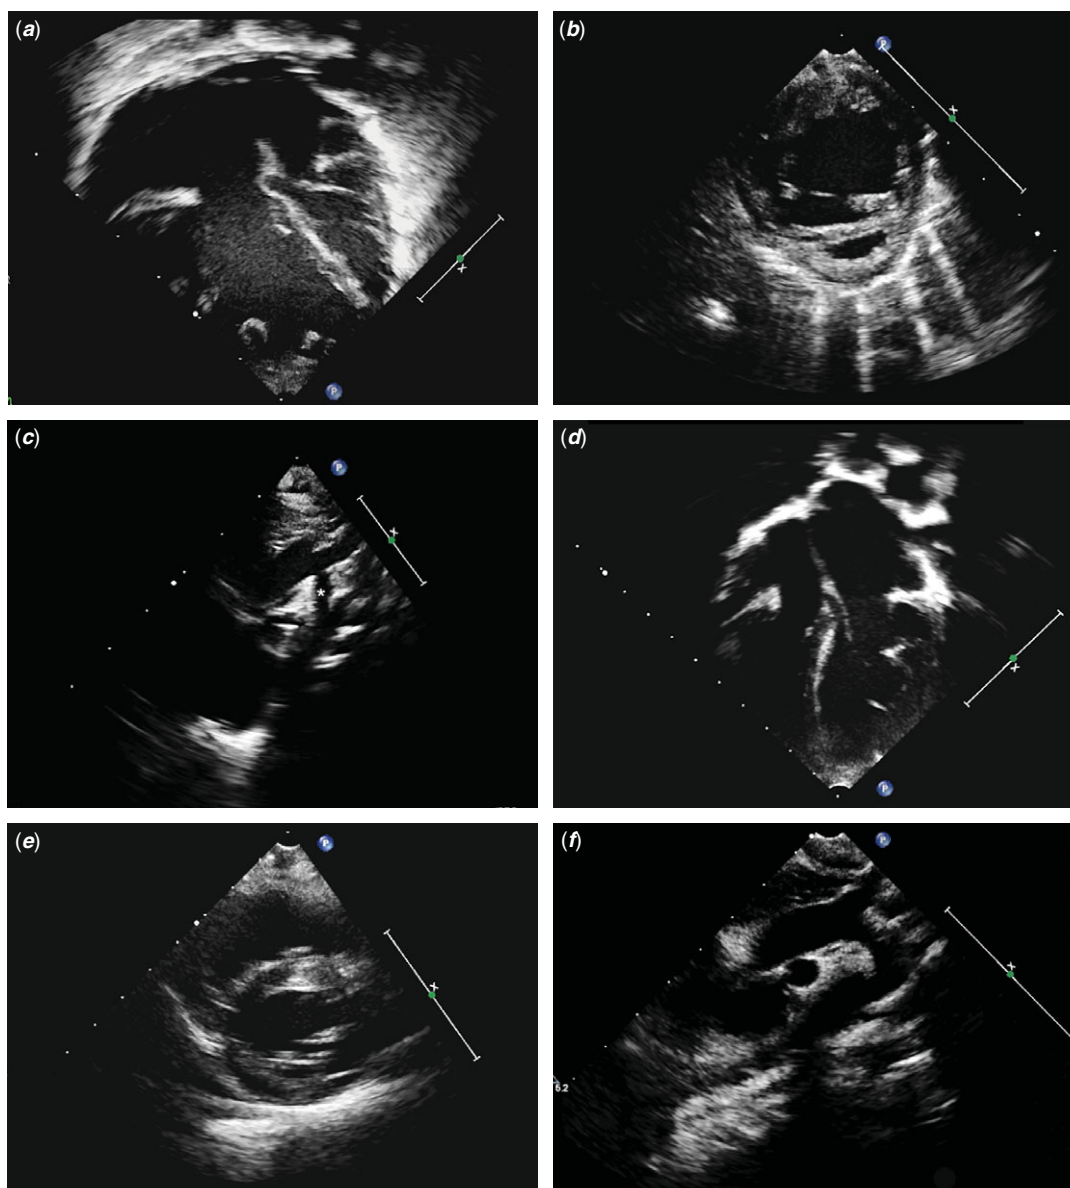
Two-dimensional echocardiographic images at birth and on the last follow-up. (a–c) Echocardiography at birth showing the small mitral valve, hypoplastic left ventricle (LV), dilated right ventricle (RV), and hypoplastic distal aortic arch (*). (d–f) Echocardiography on the last follow-up showing good growth of LV and normalisation of the size of the RV and aortic arch.
